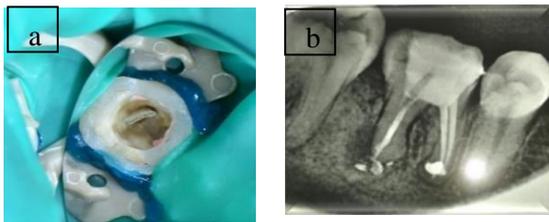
(a) Clinical view after cementing fiber post, (b) Periapical radiograph after cementing fiber post.
